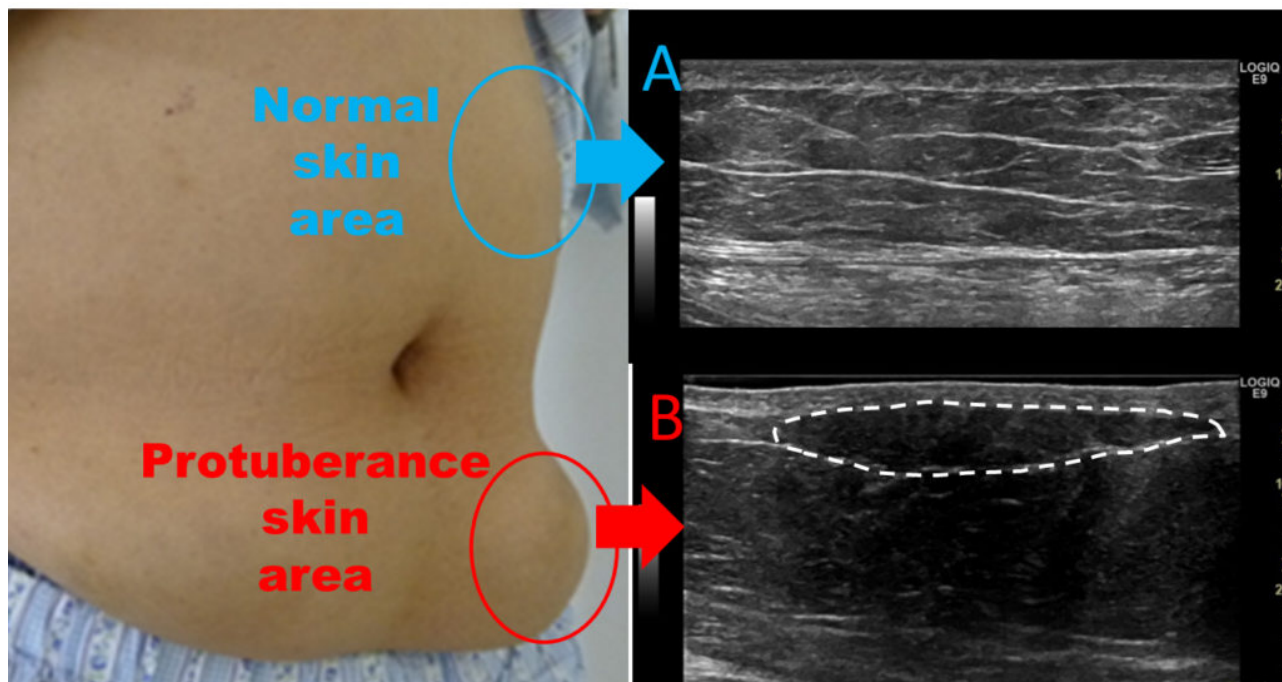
Ultrasound image of normal and protuberance skin areas on the abdominal wall
